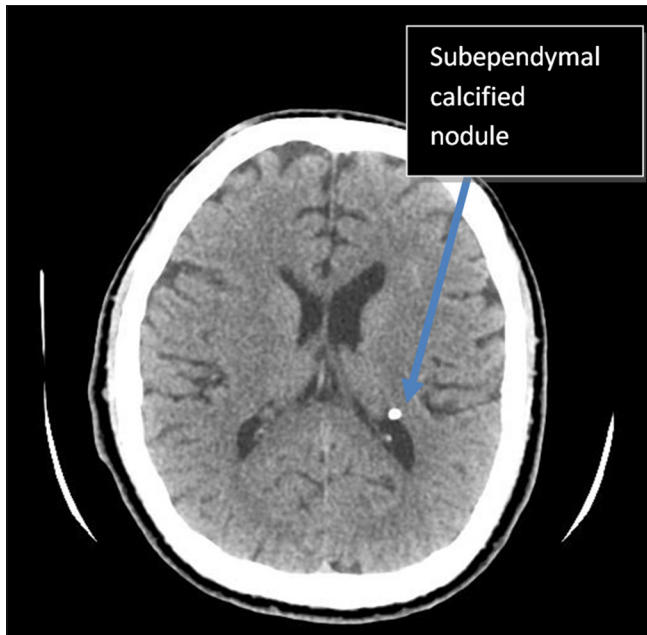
Axial non-contrast computed tomography image of the brain showing well-defined subependymal calcified nodule in the left lateral ventricle.
